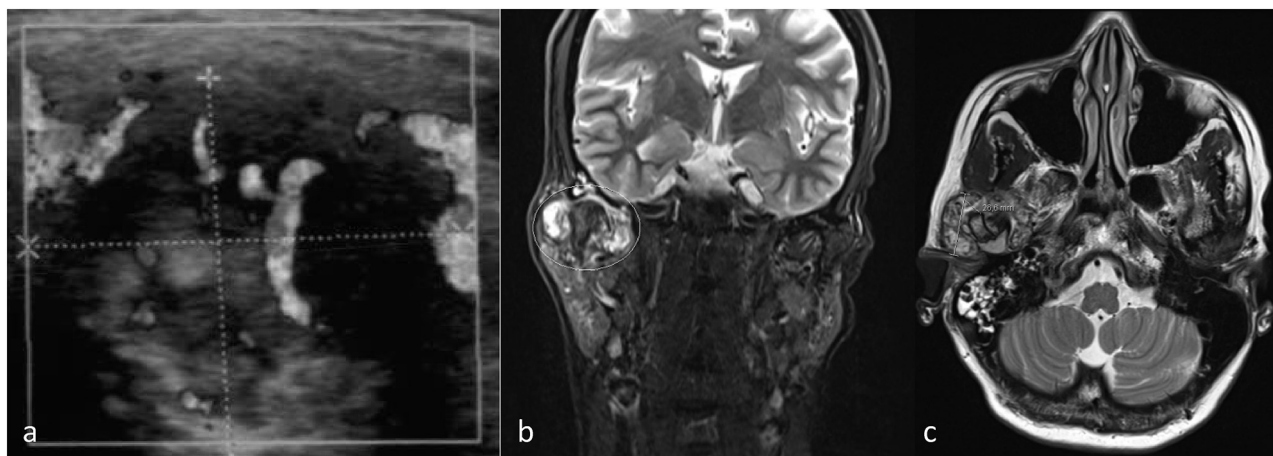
The ultrasonic scan (a) shows the intense vascularization in the area. Axial (b) and coronal (c) T2-weighted magnetic resonance images show a hyperintense mass surrounding the TMJ, in intimate contact with the synovium. The lesion also extends to medial of the joint (c).
